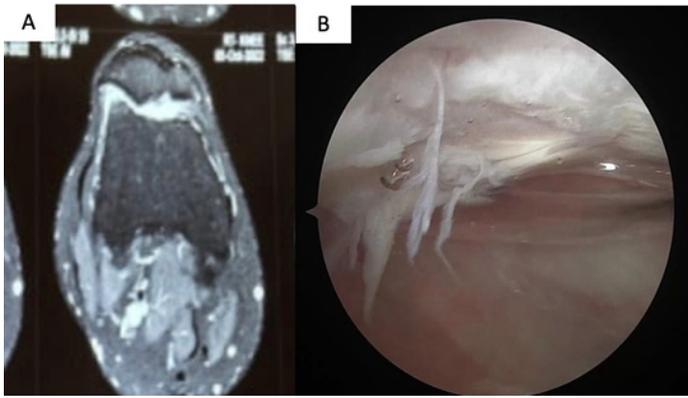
Patellar cartilage defect: A: MRI axial cuts, B: Arthroscopic image
